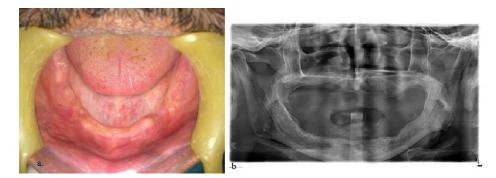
Preoperative alveolar ridge defect seen in mandibular left premolar region. Fig1.a showing clinical photograph; Fig 1.b showing preoperative Orthopantomogram
